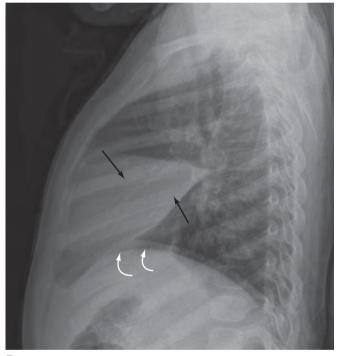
Silhouette sign. On the frontal radiograph (A), the right heart border is not visible because aerated lung has been replaced by fluid-filled lung in the middle lobe. On the lateral view (B), this is confirmed as the consolidated middle lobe is seen as a triangular-shaped density overlying the heart (*black arrows*). Note that the right hemidiaphragm remains visible on both the frontal and lateral radiographs as it is outlined by aerated lung (*curved white arrows*).
